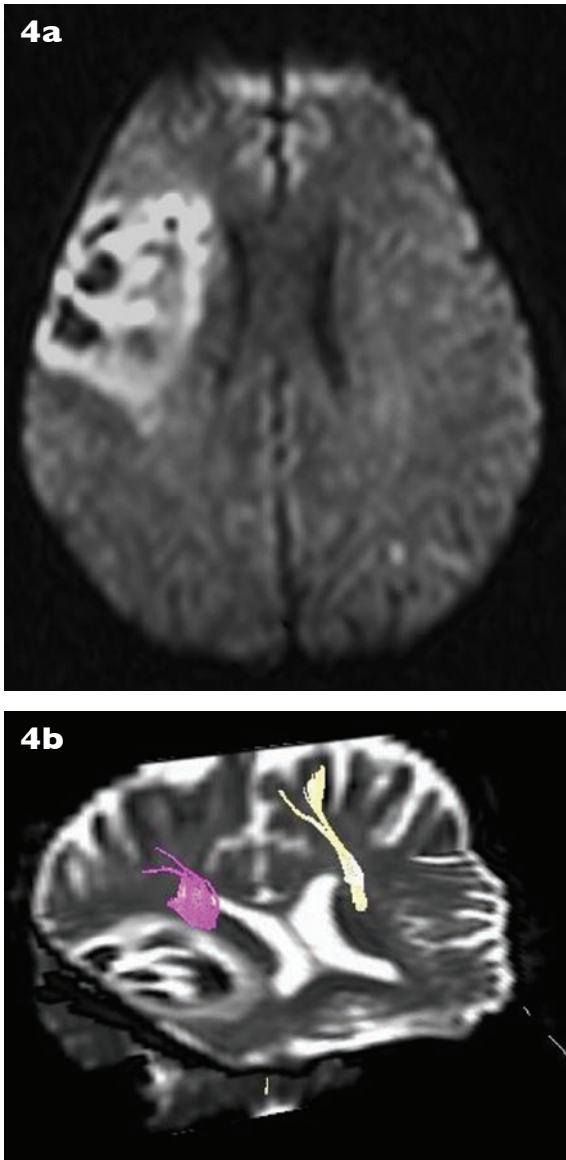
Case 4. (a) DWI shows right middle cerebral artery infarction with haemorrhagic conversion. (b) MR tractography shows displacement of right corticospinal tract due to mass effect and tissue oedema. The tract is otherwise preserved.
